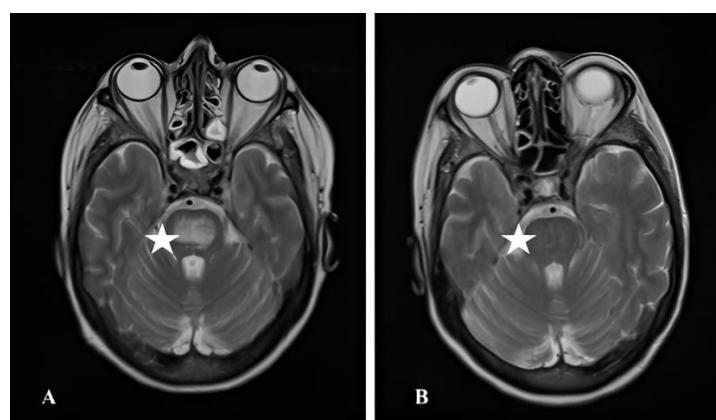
Hyperintense lesion on axial T2W MRI at pontin level. A.: Initial diagnosis, B.: After one course of therapy
